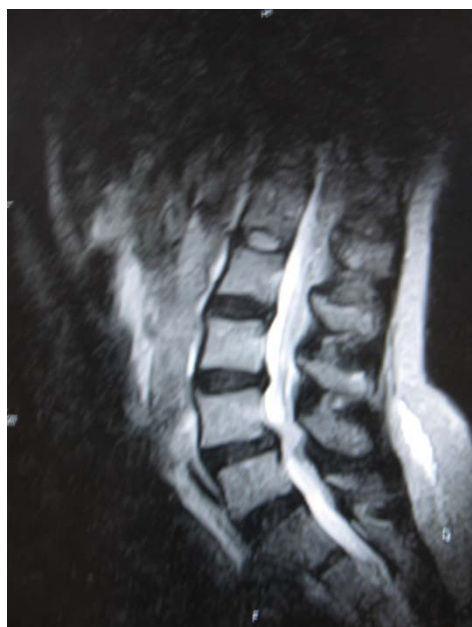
Mid - sagittal T1W MRI showing L3/L4 disc hernia.
